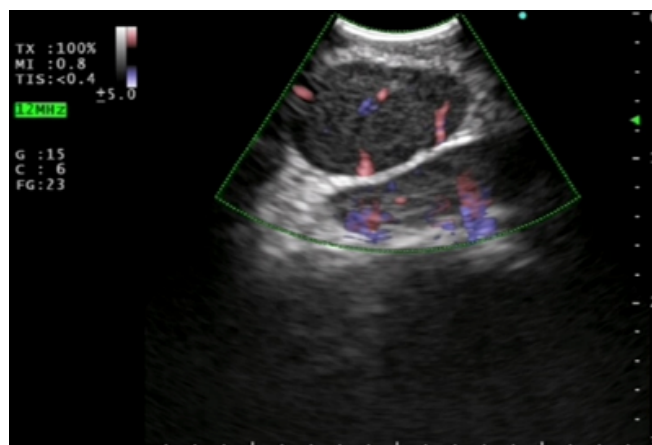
Assessment of mediastinal lymph nodes Doppler vascular pattern
